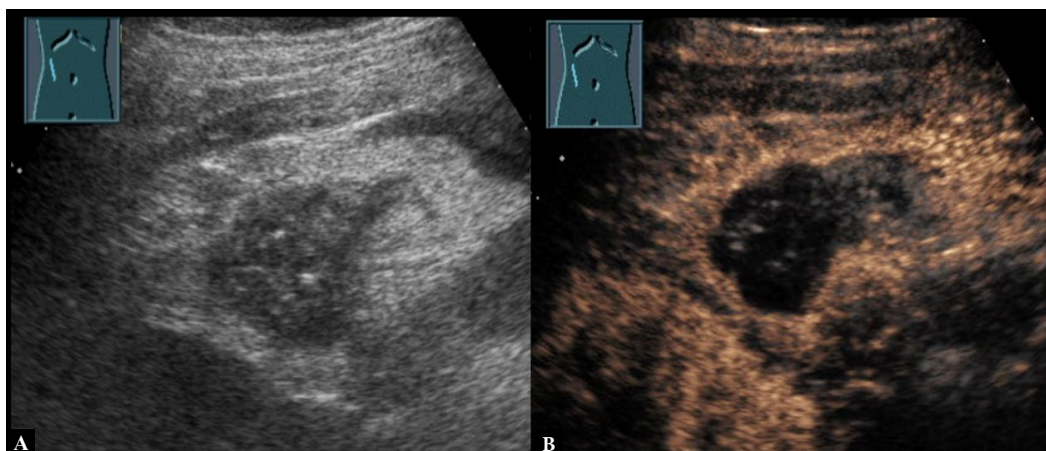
Hypoechoic lesion on B-mode US in the right upper lateral quadrant with imbibition of the surrounding fat tissue (A) and without enhancement in contrast-enhanced ultrasound (CEUS) (B)
